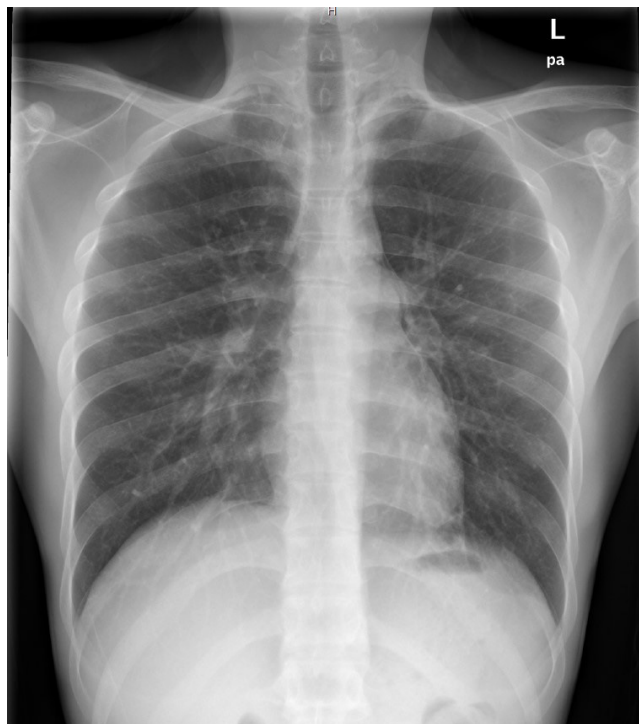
Chest Radiograph. Chest radiograph on Day-6 of admission showed complete resolution of pneumothorax and subcutaneous emphysema, and resolving pneumomediastinum.
